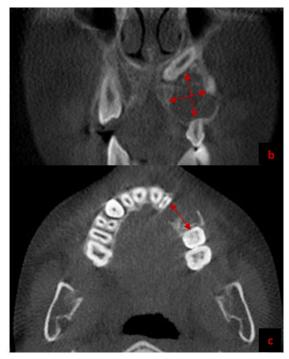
View of the lesion with cone beam computerized tomography (CBCT)(a: Saggital section, b:coronal section, c:axial section)
